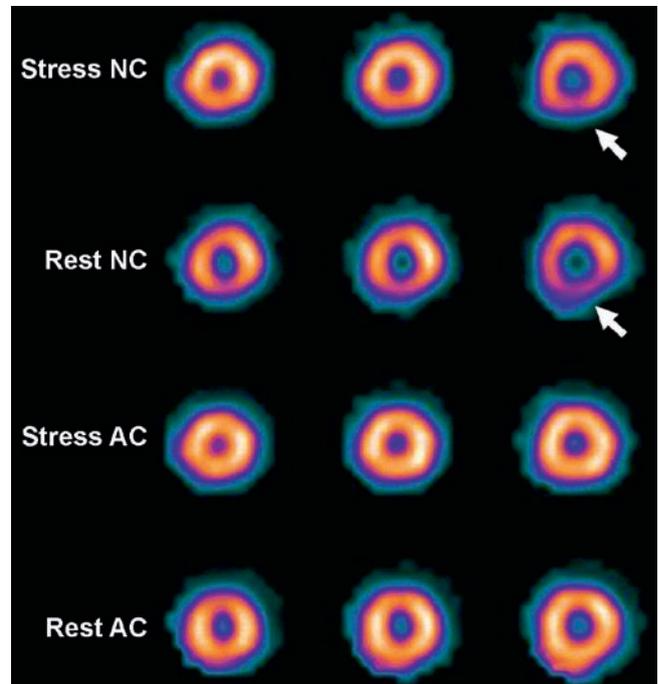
Non-corrected (NC) and attenuation corrected (AC) mid-ventricular short axis myocardial perfusion SPECT images using $^{99\text{m}}\text{Tc}$ -sestamibi in an individual with suspected coronary artery disease (CAD). Note the inferior wall defect in NC images (arrows) which resolves after AC, indicating the presence of artefact rather than disease
